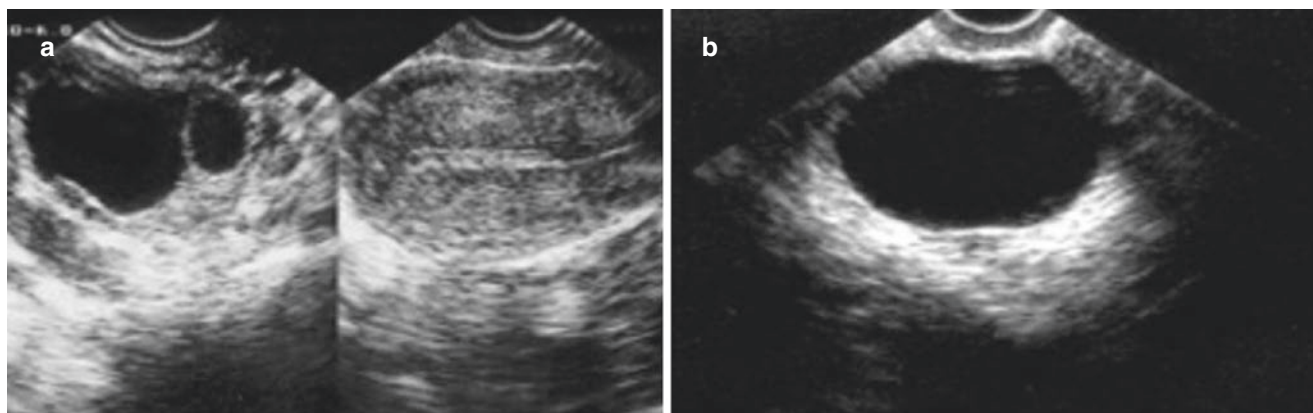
Follicular cysts. (a) Sonogram shows a cyst, 2.6 cm in diameter, with clear fluid and thin wall. (b) Sonogram shows a cyst, 4.0 cm in diameter, with clear fluid and thin wall. The cyst absorbed naturally during routine observation
